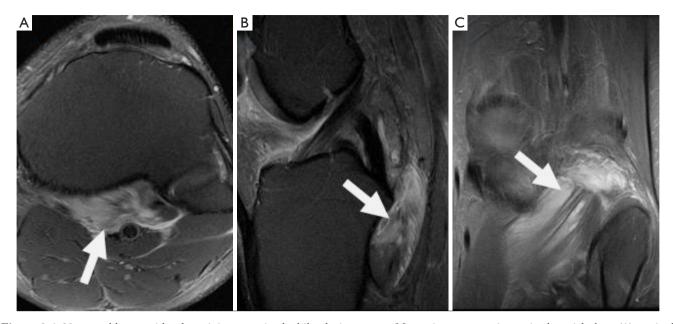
A 33-year-old man with a knee injury sustained while playing soccer. Magnetic resonance image in the axial plane (A), sagittal plane (B) and coronal plane (C) with T2 weighted sequences with fat saturation. The images show an injury at the myotendinous junction of the popliteus muscle (arrows).
